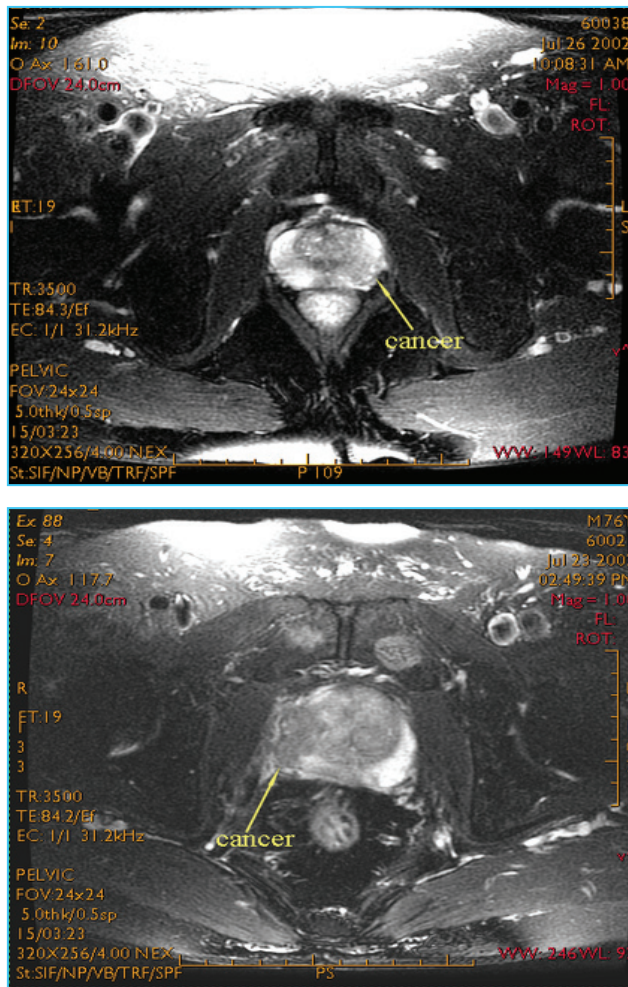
MRI- Tumor signal uneven, often on T1 Weighted as a low signal or equal signal.
